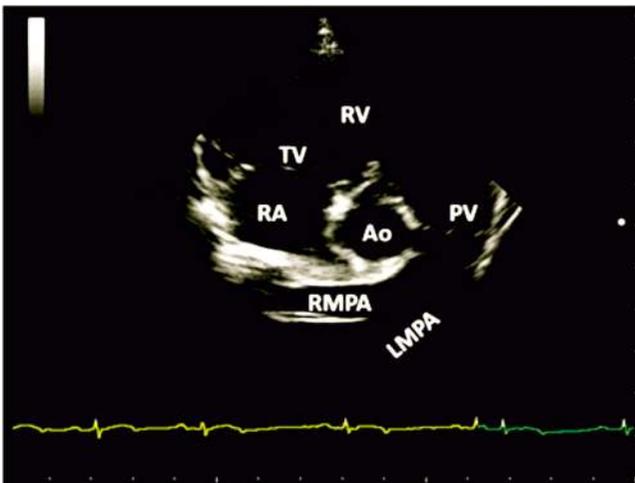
Parasternal short axis view at the heart base and pulmonary artery level (RV-right ventricle, RA-right atrium, Ao-aorta, TV-tricuspid valve, PV-pulmonary valve, RMPA-right main pulmonary artery, LMPA-left main pulmonary artery)
